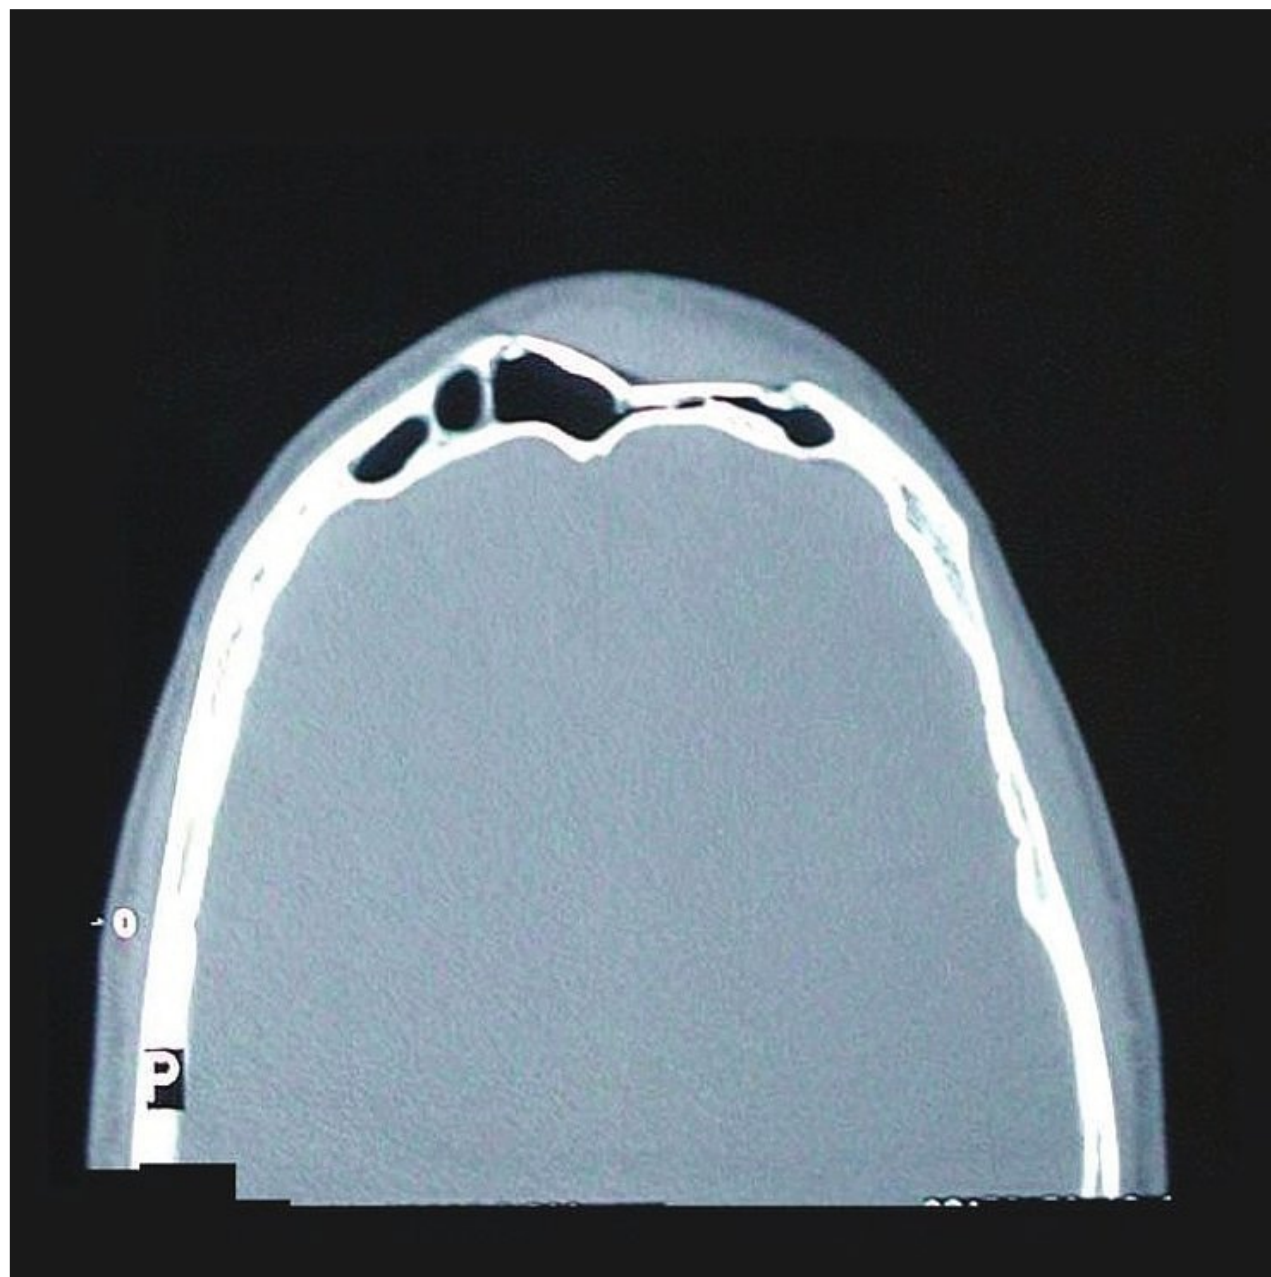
CT demonstrating an isolated fracture of the anterior table of the frontal sinus.
